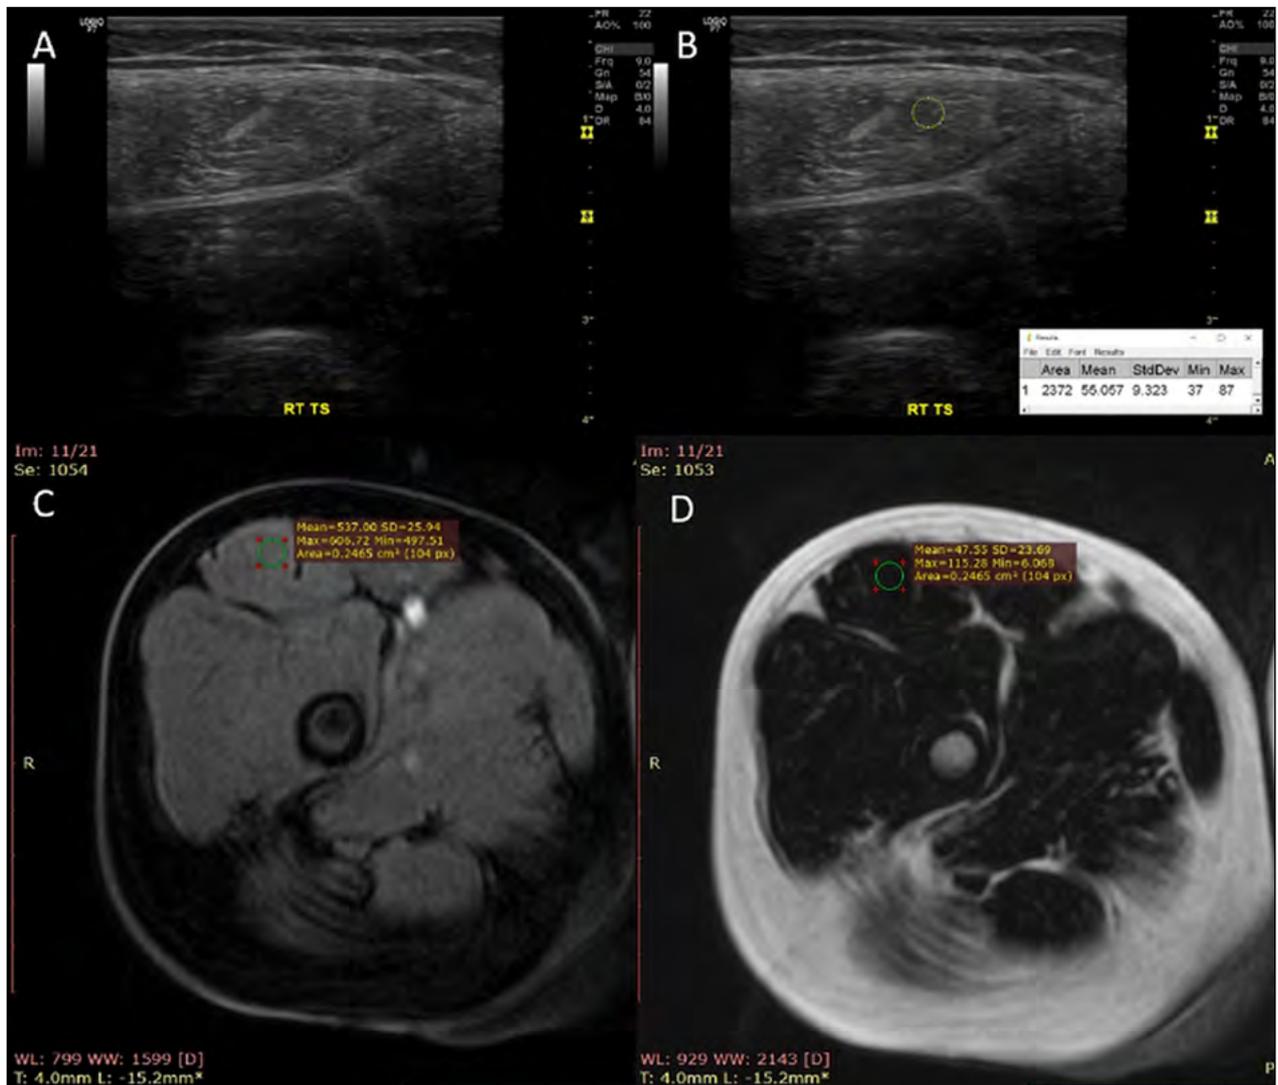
A patient with Duchenne muscular dystrophy. A) Transverse US image of the right thigh taken at the junction between the proximal 1/3 and distal 2/3 between its origin (from the anterior inferior iliac spine) and its insertion (at the upper pole of the patella) showing fatty infiltration of the quadriceps muscle as shown by increased echogenicity and blurred cortical surface of the femur; B) the same image in (A) analyzed by ImageJ software with the ROI is within the rectus femoris muscle, mean histogram, 55; C,D) axial MRI image (mDixon sequence) with the region of interest (ROI) within the right rectus femoris muscle at the junction between the proximal 1/3 and distal 2/3 between its origin (from the anterior inferior iliac spine) and its insertion (at the upper pole of the patella), mean fat & water signals were 66 and 546 respectively.
